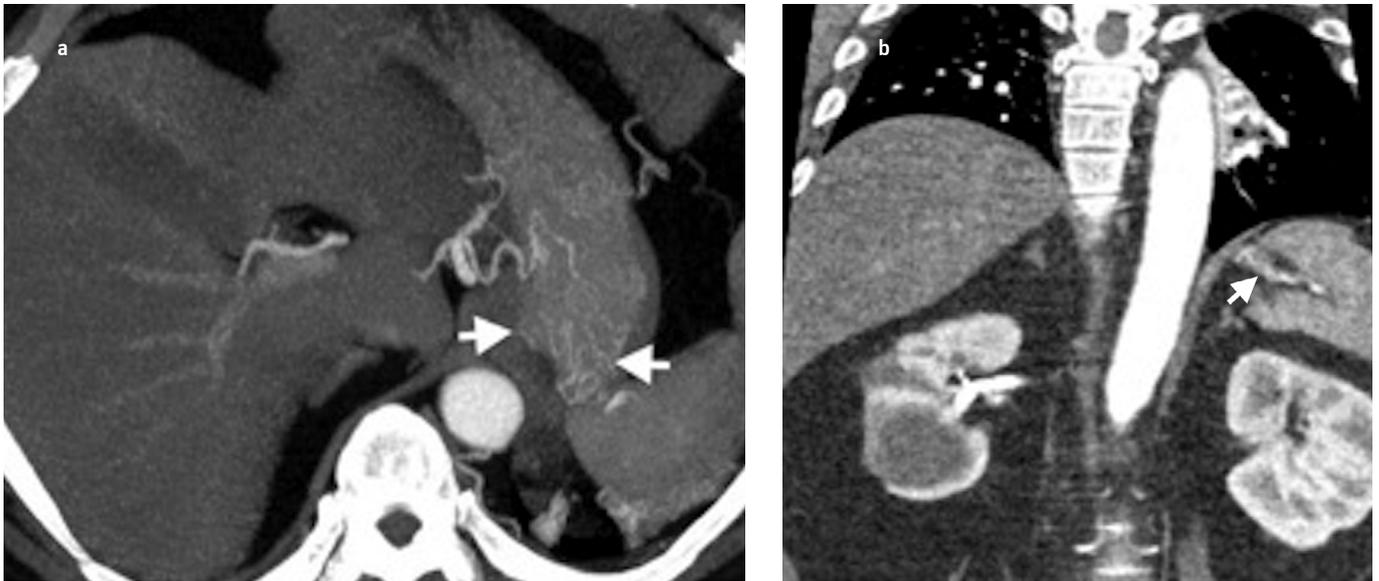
a, b. Collateral vessels in the gastric wall (a) Maximum intensity projection (MIP) image of CTA at arterial phase reveals tortuous vascular structures (arrows) in the gastric fundus. (b) Coronal CTA shows an extension of vascular structures in the gastric fundus to splenic hilum (arrow)
